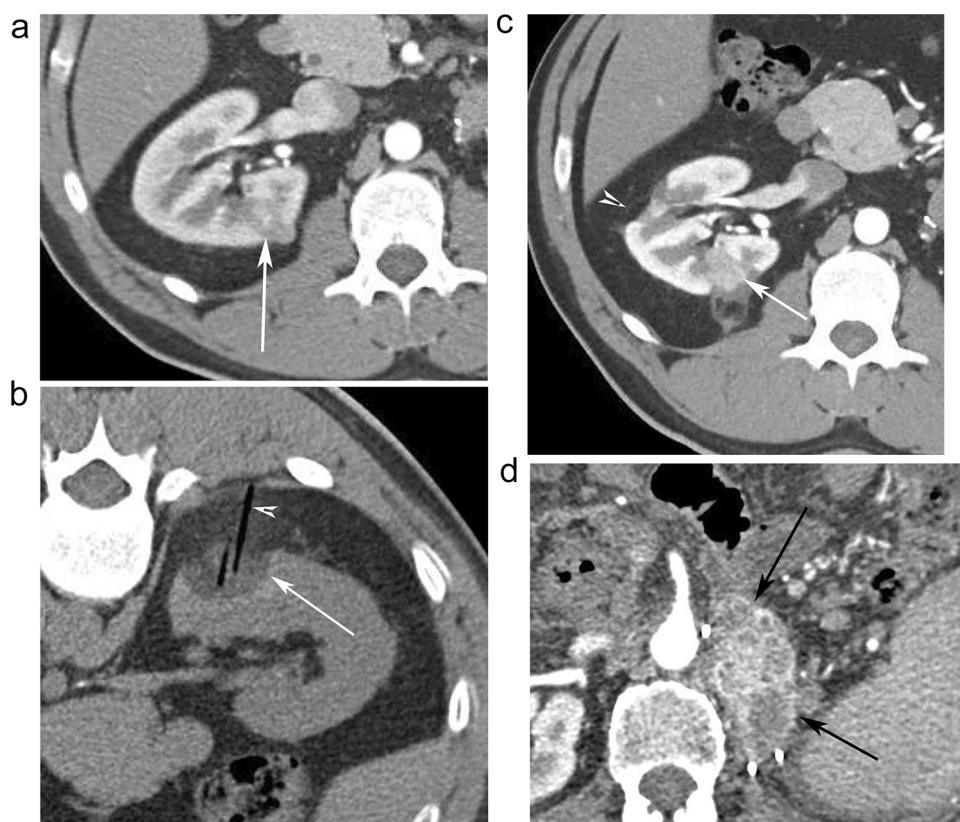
RCC recurrence post-ablation and local recurrence in the nephrectomy bed. (a) 43-year-old male with clear cell RCC of the left kidney, status post radical left nephrectomy, now with metastatic lesion in the right kidney. Axial CT image of the abdomen shows an enhancing mass in the mid-pole of the right kidney (arrow). (b) Axial CT image of the abdomen in the same patient during cryoablation for the mass in (a). Note the cryoablation probes (arrowhead) within the mass (arrow). (c) Axial CT image of the abdomen 9 months following cryoablation shows enhancing nodule in the ablation zone (arrow), consistent with local recurrence. Incidental note of cortical scarring in the anterolateral aspect of the kidney (arrow head), not present on the pre-procedure scans (not shown), likely sequela of cryoablation. (d) 69-year-old male with clear cell RCC of the left kidney, status post radical left nephrectomy. Axial CT image shows heterogeneously enhancing mass in the left nephrectomy bed, consistent with local recurrence.
